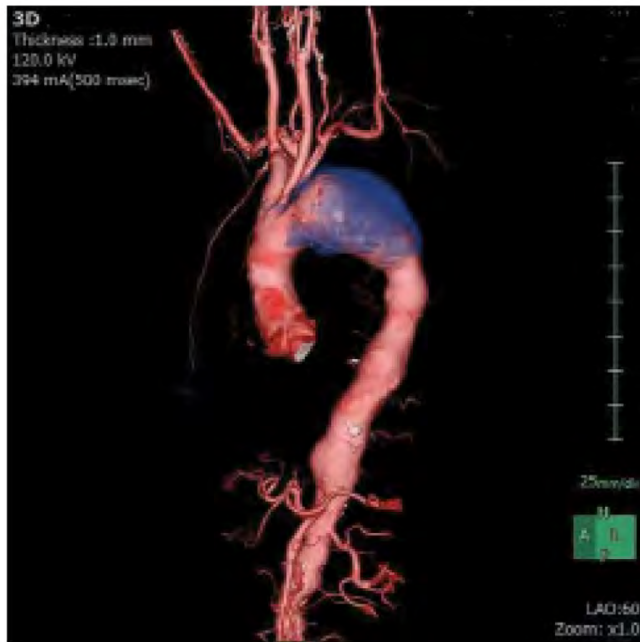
A preoperative computed tomography scan showed a thoracic aneurysm extending from the level of the left subclavian artery to a level below the hilum of the left lung.
